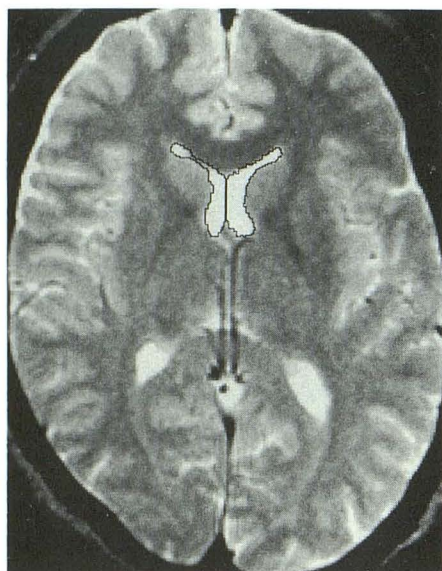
Measurement of frontal horn area on MR image (2500/80/1). Area of frontal horns was measured on slice where bicaudate ratio, bifrontal ratio, and bifrontal distance/bicaudate distance were obtained. This is slice in which frontal horns are clearly visible and septum is thinnest.
